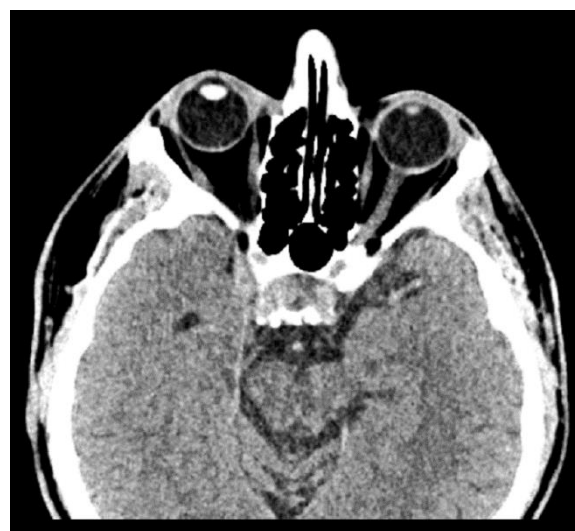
CT image of the patient in axial plane. There were no signs of inflammation of the sphenoid and ethmoid sinus. *Slika 1b. CT slika bolesnika u aksijalnoj ravnini. Nije bilo znakova upale sfenoidnog i etmoidnog sinusa.*
